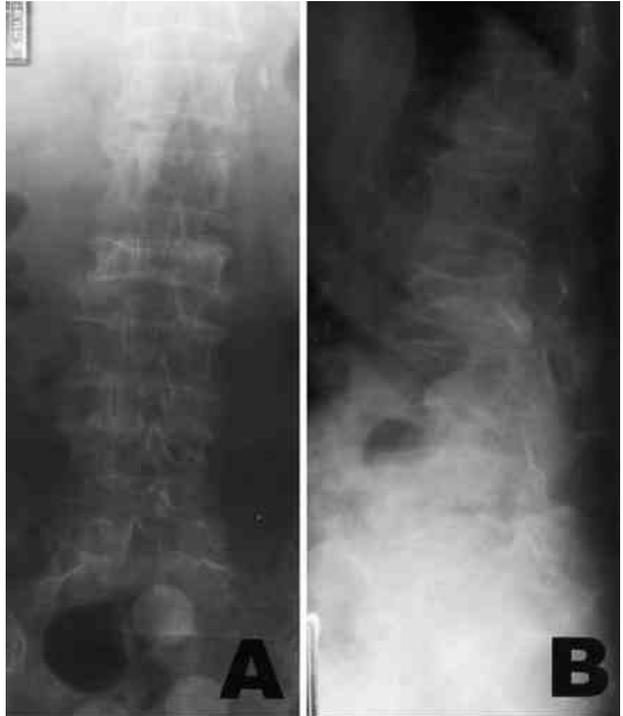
The plain roentgenography of 73-year old female patient. The AP (A) and lateral (B) films show type 2, biconcave fracture of L2 vertebral body and slight height loss of L3 vertebral body.
